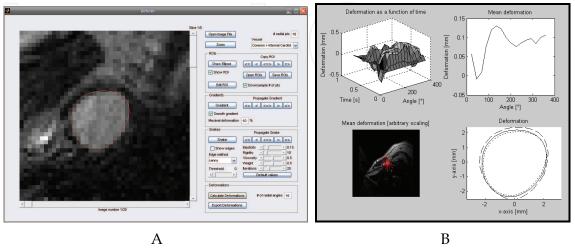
Custom Matlab toolbox for measuring time-resolved deformation. A: Crosssectional B-TFE MRI scan with contour of CCA outlined in red. B: Top left: Deformation as a function of time and radial angle. Top right: mean deformation as a function of radial angle. Bottom left: Mean radial deformation overlaid the MRI scan. Bottom right: Mean (solid line), maximal (dashed line), and minimal (dotted line) deformation
